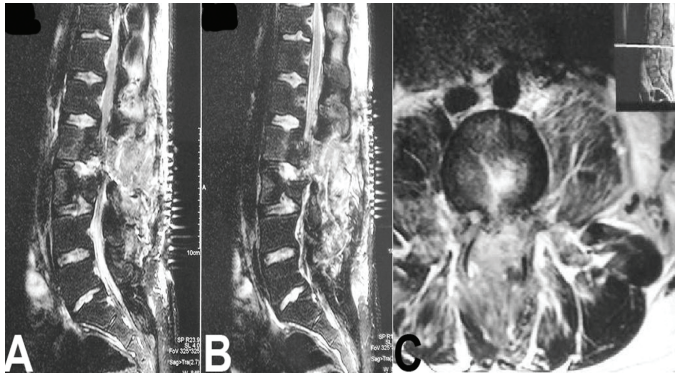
Postoperative sagittal (A, B) and axial (C) T2-weighted MRI scans of a patient with SGW at L3 level. Spine, spinal cord and paravertebral soft tissues were significantly damaged by a high-velocity bullet
